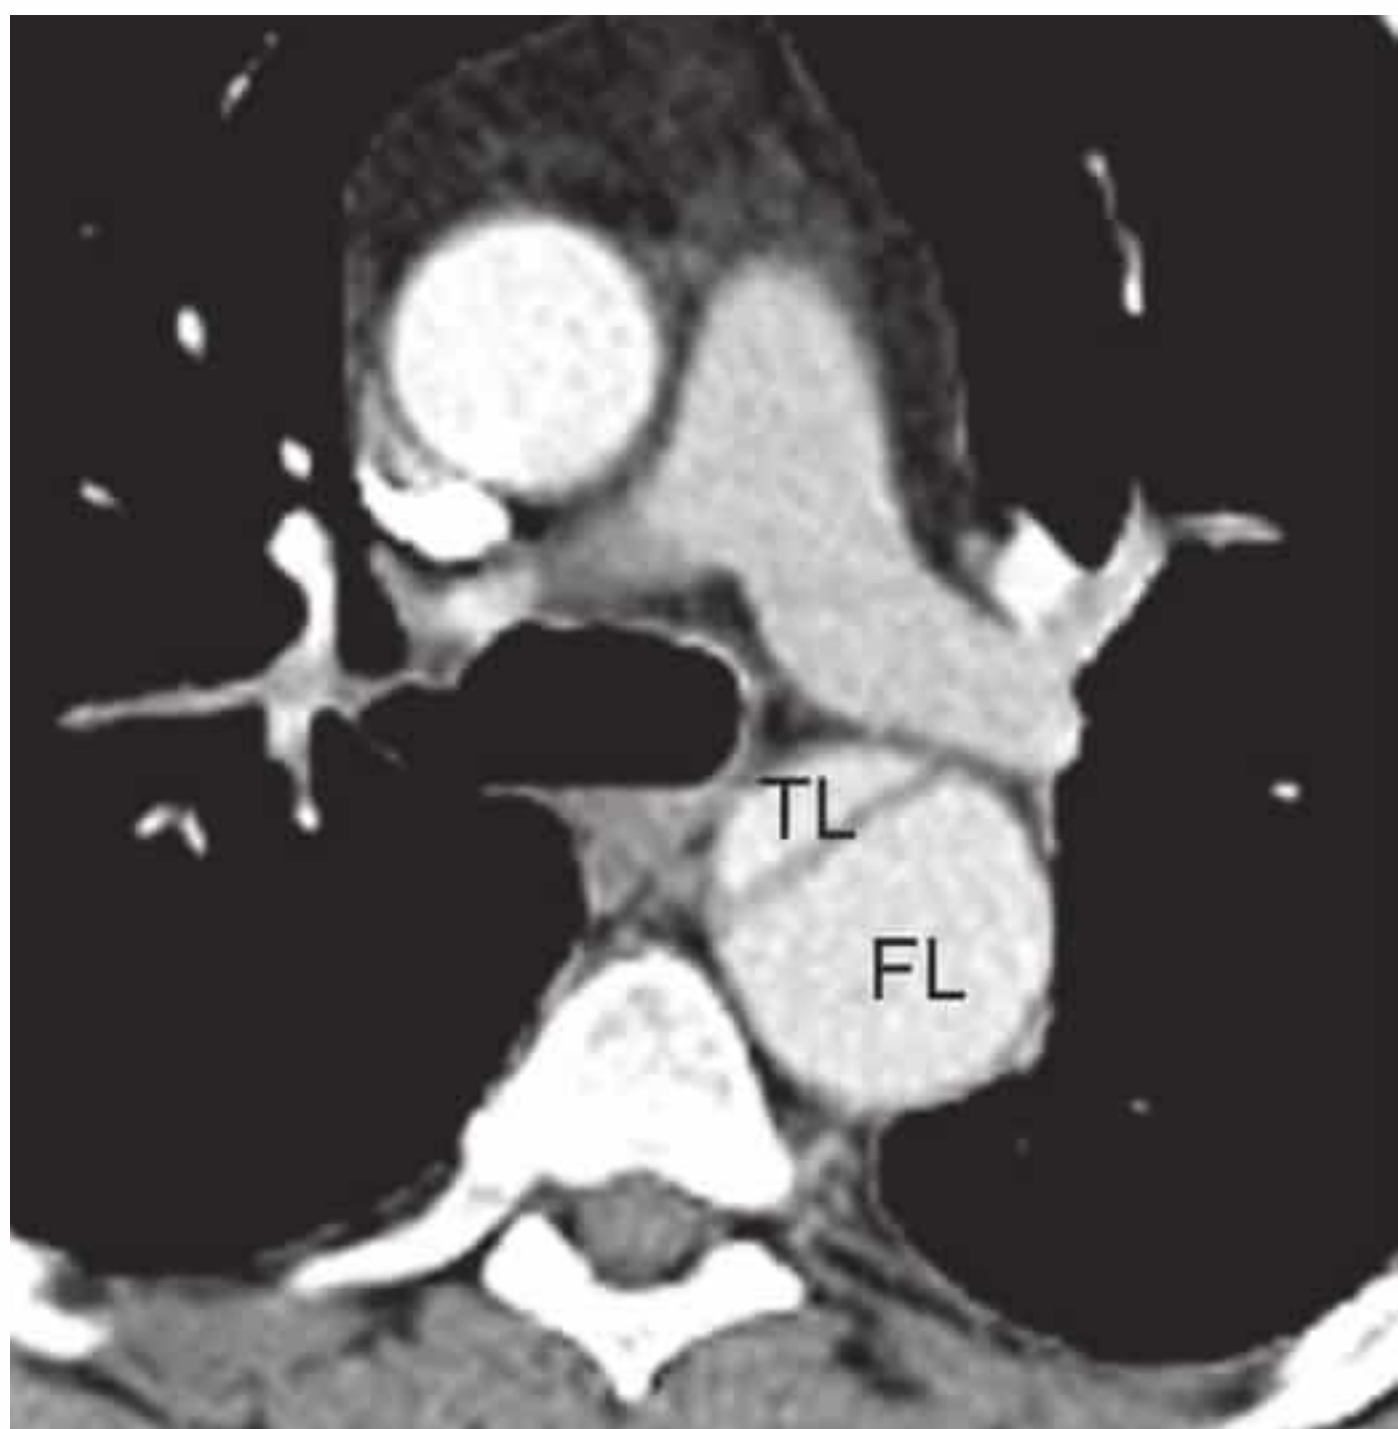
Contrast-enhanced CT demonstrates an intimal flap in the descending thoracic aorta with the development of true (TL) and false (FL) lumina.
